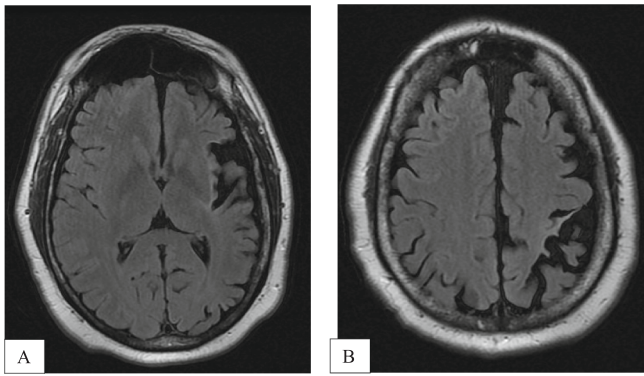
Pre-surgical axial MRI brain of patient 1 showing moderate left cerebral hemispheric atrophy, most severe within the left insular cortex, parietal lobe, and temporal operculum. There are enlarged left parafalcine subarachnoid spaces due to the unilateral left-sided atrophy. There are apparent increases in the left hemispheric sulcal spaces compared to the scan done 7 years earlier, consistent with the history of clinical progression.
